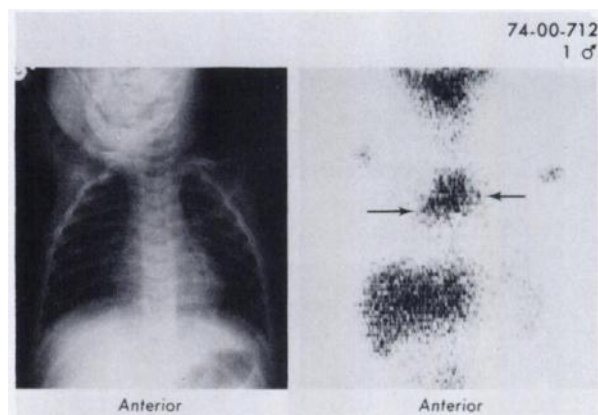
One-year-old boy with meningitis, evaluated for possible cerebral or other abscess. Markedly increased accumulation of Ga-67 is seen in thymus, with typical "notches" at edges of right and left lobes (arrows). X-rays never showed thymic enlargement, and the child remained well 2 yr following recovery from meningitis (see text).
